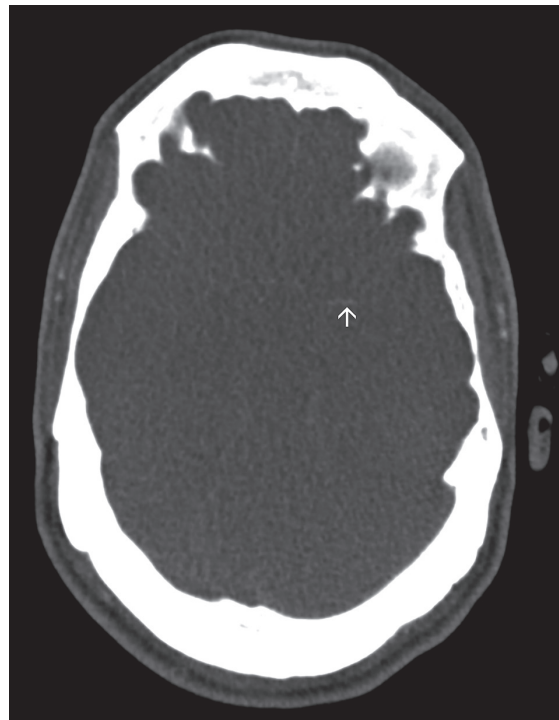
CT angiography of the carotid circulation.
